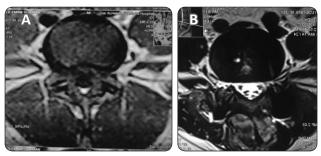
(A) Pre- and (B) post-operative axial T2 MRI of L4-5 level showing bilateral foraminal decompression.
